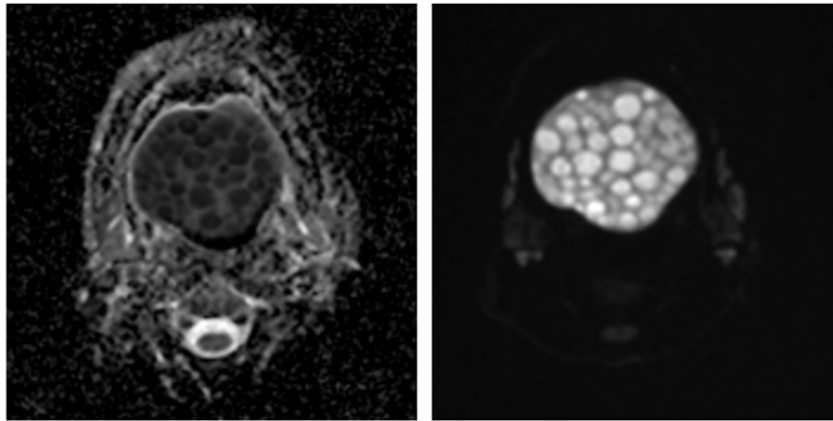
24-year-old male with epidermoid inclusion cyst in the sublingual space. FINDINGS: The lesions display the classic “sack-of-marbles” pattern - multiple, rounded foci of marked hyperintensity on DWI that correspond to low-signal areas on the ADC map, confirming true diffusion restriction. TECHNIQUE: Diffusion weighted images (DWI) and apparent diffusion coefficient (ADC) map in transverse planes. b=0,1000; TE 106, TR 10800; 4 mm slice thickness; 1.5 Tesla magnet.
